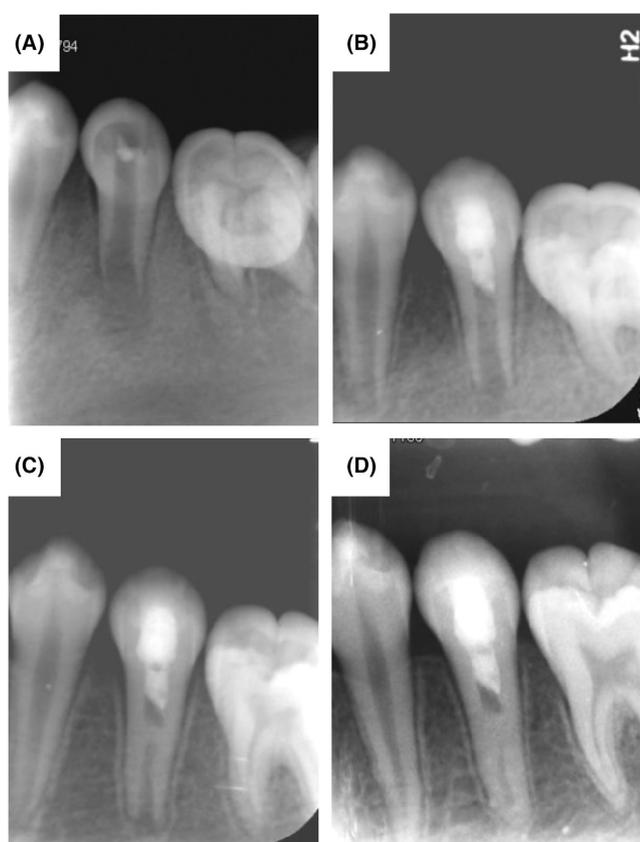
A 10-year-old female patient diagnosed with an acute apical abscess. Periapical films of tooth 35 over a 51-month follow-up duration. (A) A preoperative periapical film showing an incompletely developed root with an extensive periapical lesion and an open apical foramen. (B) A 4-month follow-up periapical film showing complete resolution of the apical lesion and healing of the periapical bone, in which the root continued to develop. (C) A 13-month follow-up periapical film: a calcific barrier formed in the canal between the coronal sealing material and the root apex. (D) A 51-month follow-up periapical film: the root achieved complete development, and the extent of calcification increased, but the root canal image was still visible.
